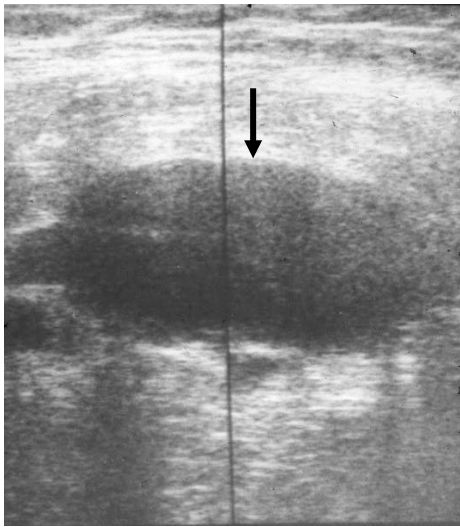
Ultrasound examination of abdomen cavity. Sharply increased abdomen part of the aorta (arrow). Abdominal aortic aneurysm [32]
